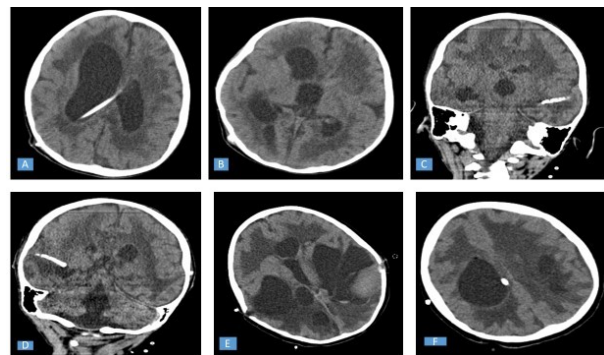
A: The 5-year-old male patient's infected VP shunt catheter is observed in the ventricle on the axial brain CT image. B: The patient's infected VP shunt catheter was removed, and her trihydrocephalus persists. C: Coronal brain CT showing external catheter placed in the left temporal ventricle D: Coronal brain CT showing external catheter placed in the right temporal ventricle. E: Demonstration of multiloculated hydrocephalus on axial brain CT. F: Showing external catheter tip on axial brain CT.
